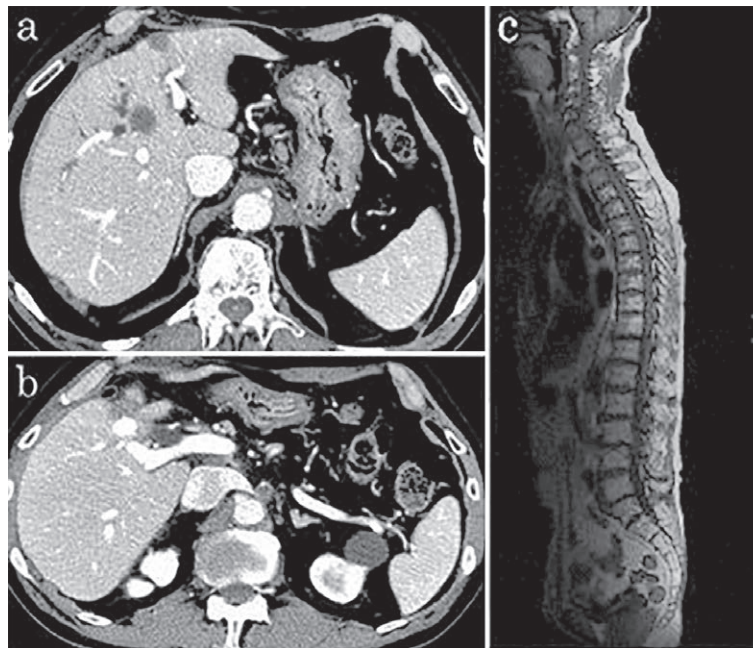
Abdominal computed tomography (a, b) and whole-spine magnetic resonance imaging (c) after 8 months of treatment. There was no evidence of hepatocellular carcinoma recurrence around the segment 5 operation site (a), and multiple lymph node (b) and bone (c) metastases had disappeared.
